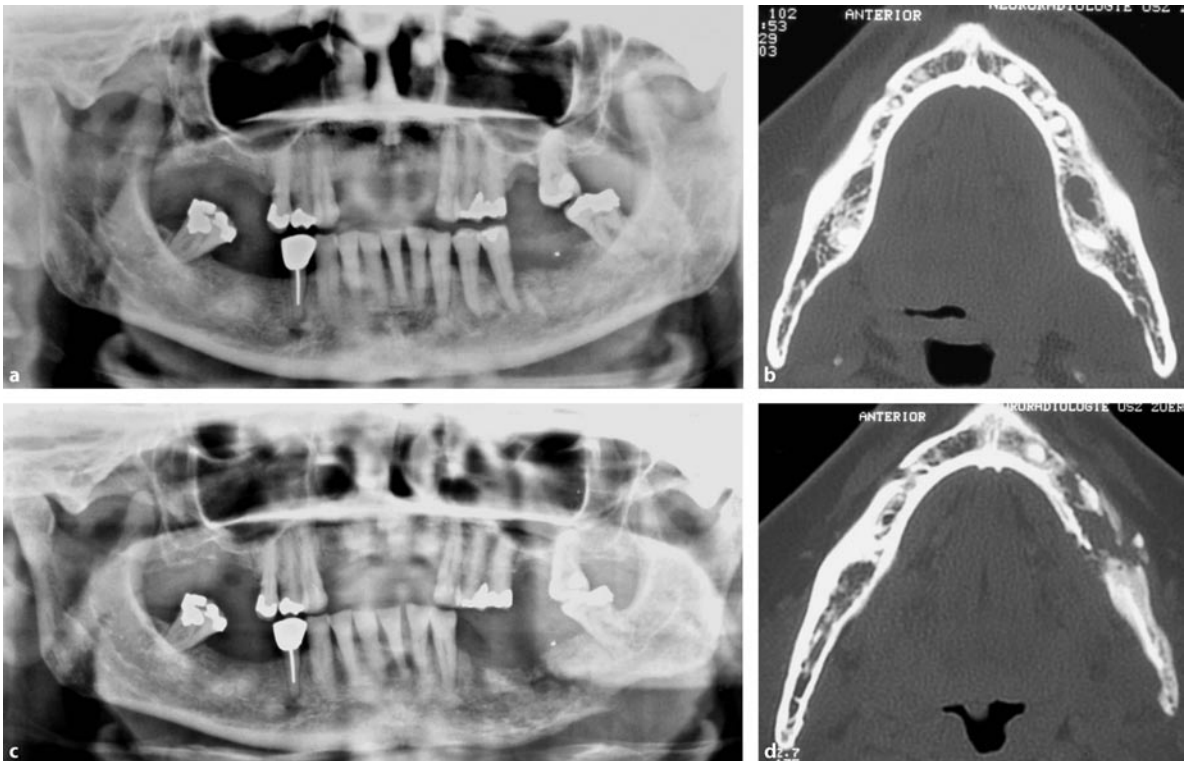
Acute osteomyelitis and transition into secondary chronic osteomyelitis with sequestration and pathological fracture: a 63-year-old woman 2.5 weeks after extraction of carious left lower molar with new onset of left mandibular swelling. Panoramic view (a) does not provide any clue to the presence of osteomyelitis. The axial high-resolution bone-window CT image (b) displays slight thinning, demineralization and endosteal resorption of lingual cortical plate. Three months later (during second course of antibiotic therapy), the patient presents with sudden onset of pain and marked malocclusion. The
